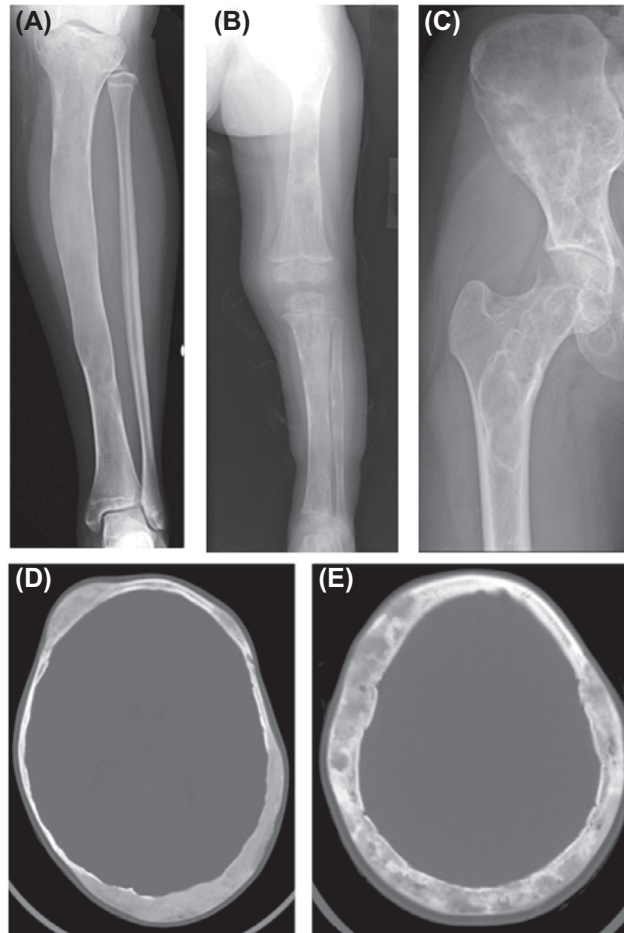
Radiographic appearance of fibrous dysplasia of bone. (A) The classic description of the radiographic appearance of fibrous dysplasia of bone (FD) is “ground glass,” which is depicted in the tibia. (B) In very young children, there is more of a streaked appearance, and (C) in older patients with less active disease there is often a sclerotic rim around FD lesions. (D) On computed tomographic scanning in young children the appearance is, again, homogeneous and ground glass, but (E) with age, the appearance is inhomogeneous, mottled, and sometimes reported to be “cystic.”
